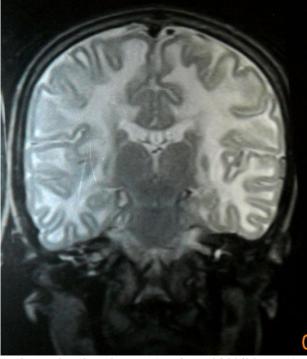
T2-weighted (TR/TE: 2200/90 msec) coronal image demonstrate high signal white matter Parietal and temporal lobes
